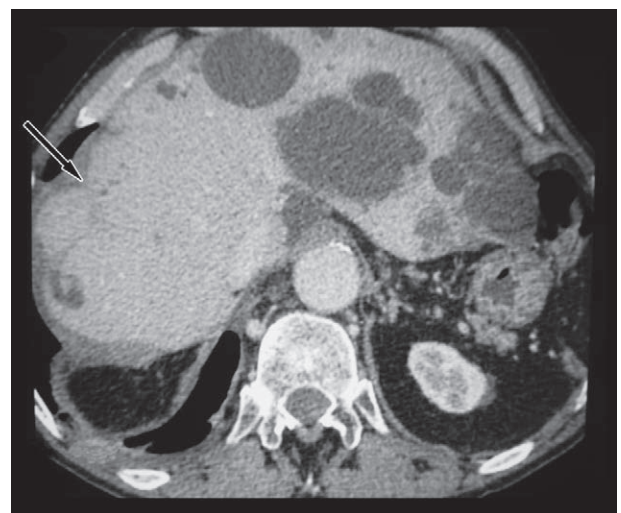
A control postoperative CT scan performed three months later shows moderate hypertrophy of the right lobe of the liver. Also visible a small scar at the site of previous hemangioma, with no signs of recurrence (arrow). Multiple cysts presented in the remaining liver.
